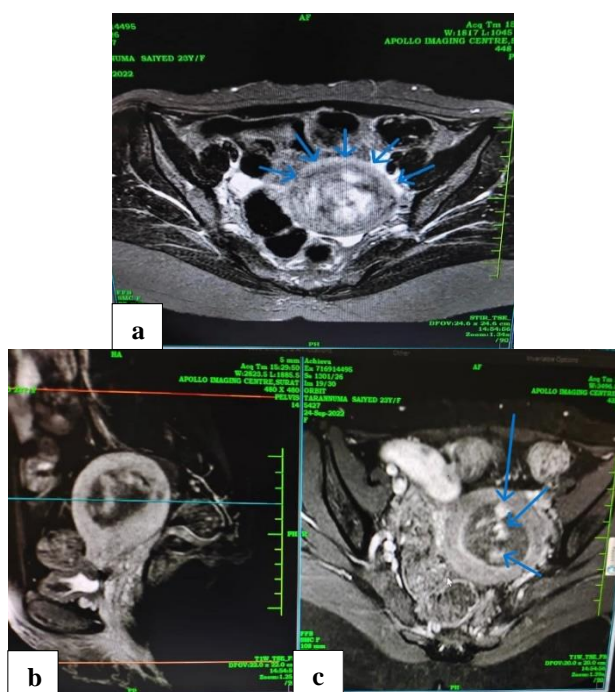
(a) and (b) MRI images of 23-year-old women who delivered 1.5 months back; coronal section suggestive of T2 weighted images showing hyperintensities in the uterine cavity. It shows heterogenous structure of size (46×43 mm) in endometrial cavity, adherent with the myometrium.
